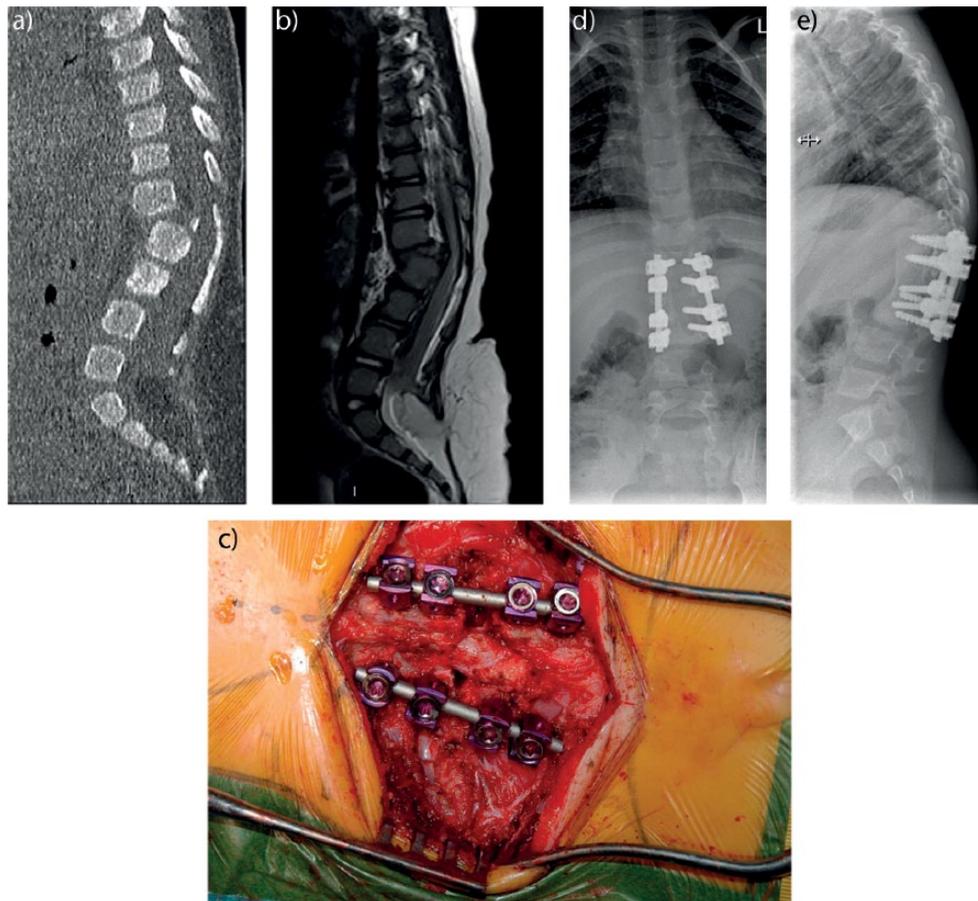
a) Sagittal CT reformat on a nine-month-old boy with congenital dislocation of the spine (type A, small rudimentary hemivertebra at the dislocation); b) sagittal T2 MR image demonstrating cord compression and tethered cord with lipomenigocele; c) intraoperative photograph after posterolateral decompression of the cord via costotransversectomy; d) and e) standing posteroanterior and lateral radiographs three years after index surgery (anteroposterior spinal fusion) demonstrating solid spinal fusion.
